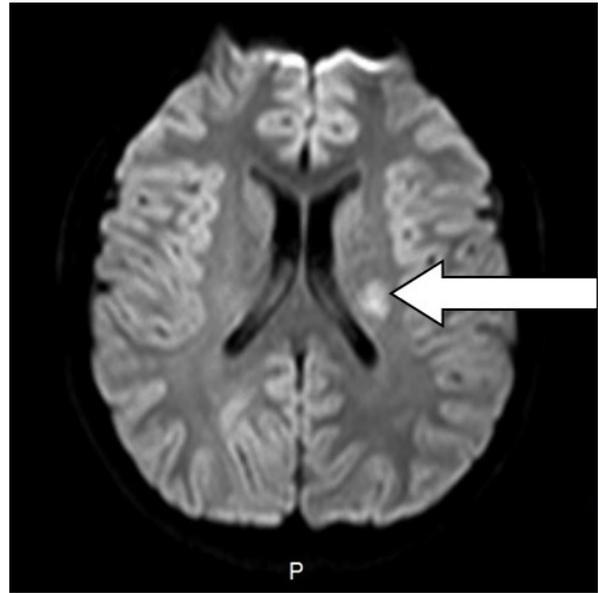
Acute İnfarction on Diffusion weighted MRI.
